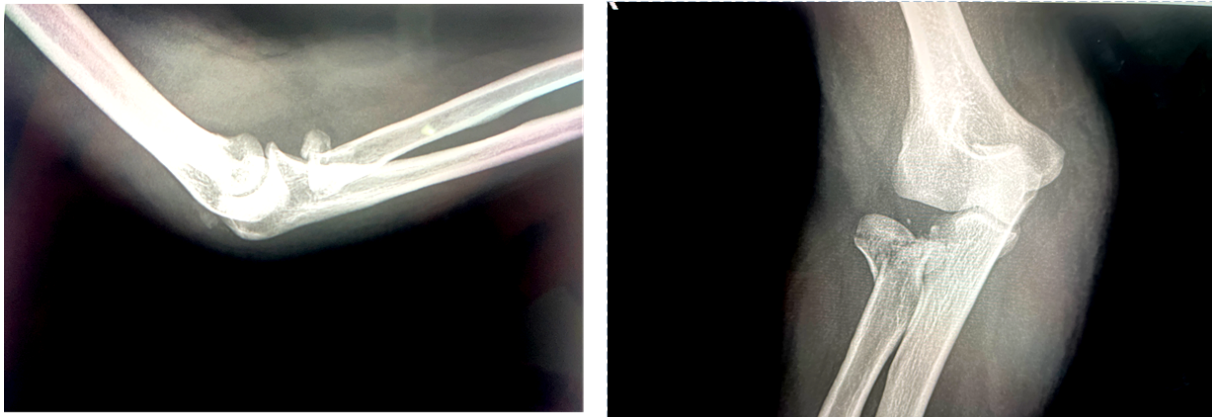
Radiographic evidence of triceps tendon avulsion associated with an atypical terrible triad injury of the elbow
